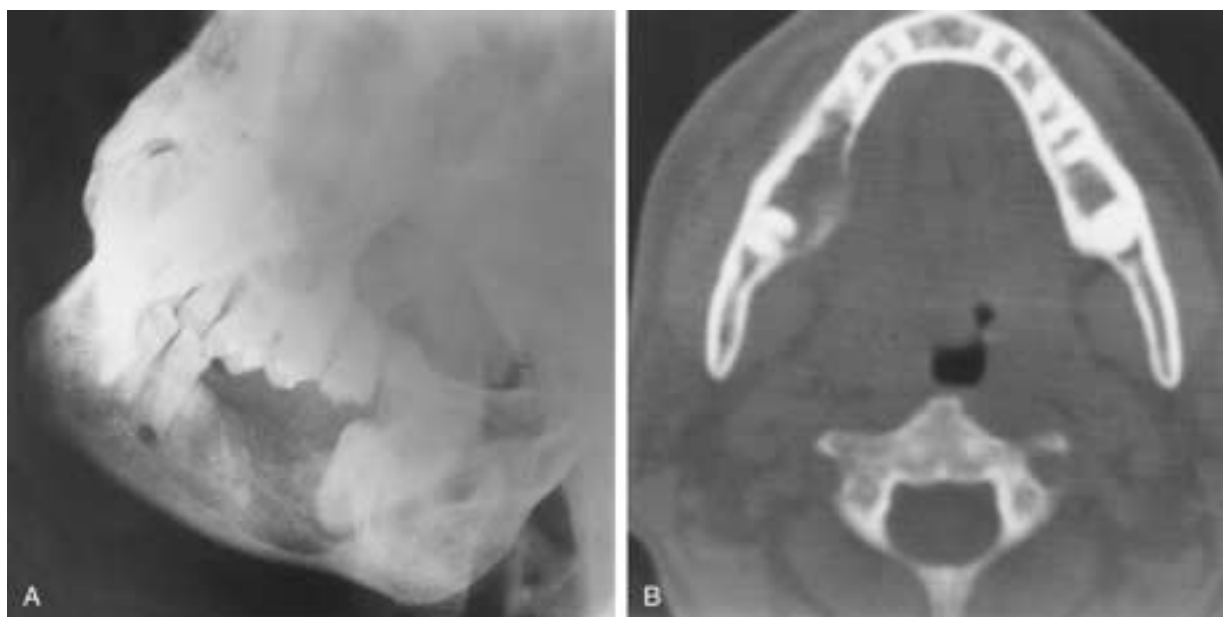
Osteogenic sarcoma of the mandible. A, Oblique view of the mandible shows an ill-defined lucent area in the body of the right mandible. There is loss of the lamina dura of the remaining third molar tooth. There is also invasion of the mandibular canal. B, Axial CT (bone window setting) shows ill-defined destruction, with expansion of the body of the right mandible.
